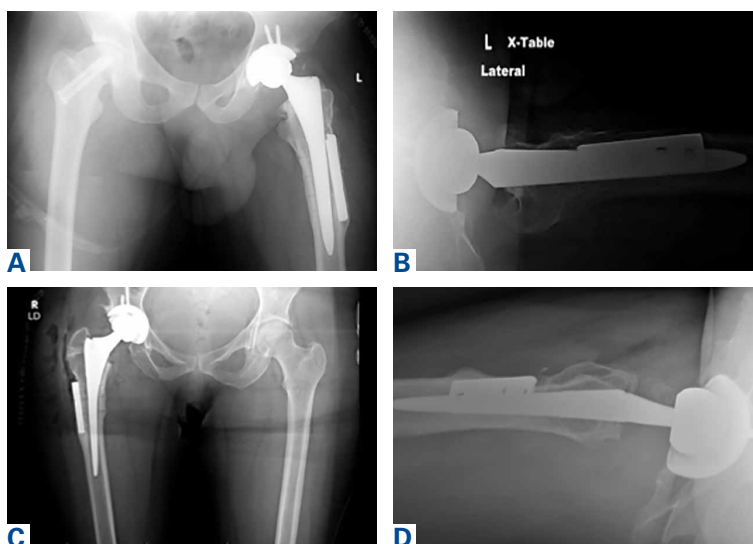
Postoperative (A) case 1 anteroposterior radiograph of pelvis, (B) case 1 cross-table lateral radiograph of left hip, (C) case 2 anteroposterior radiograph of pelvis, and (D) case 2 cross-table lateral radiograph of right hip.
